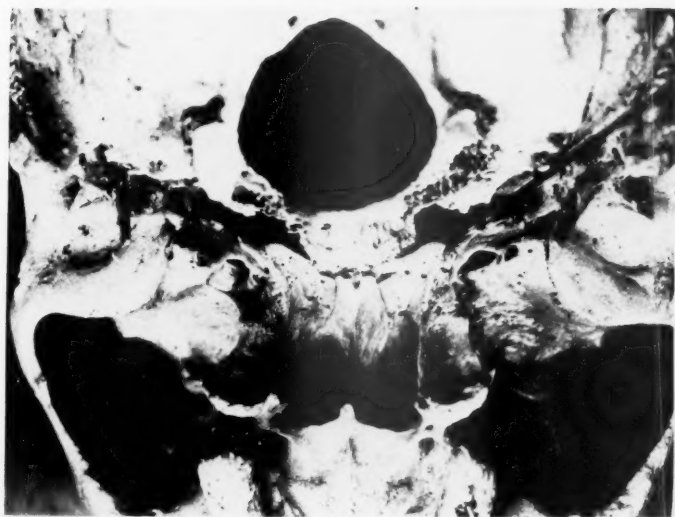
Carotid canals converted into carotid grooves by enlargement of the internal carotid artery. This view indicates the relation in the mento-vertical roentgenogram.
